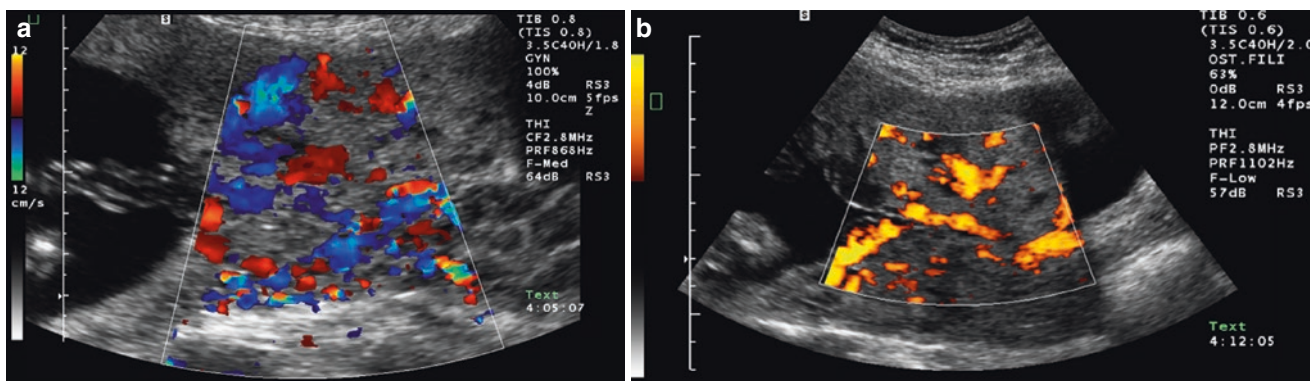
Placenta previa accreta – multiple vascular lacunae at color Doppler
